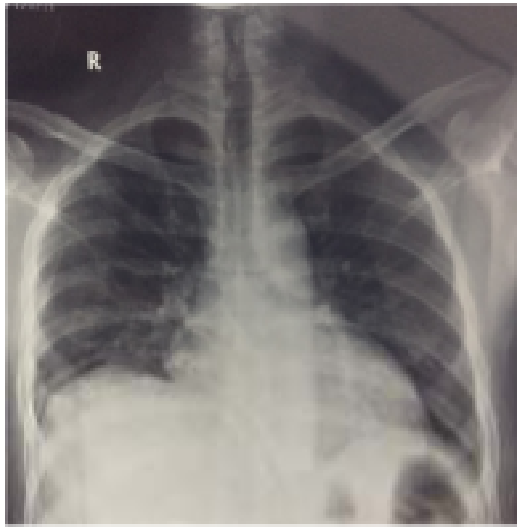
Repeat Chest x-ray after 3 weeks showing radiological clearance
